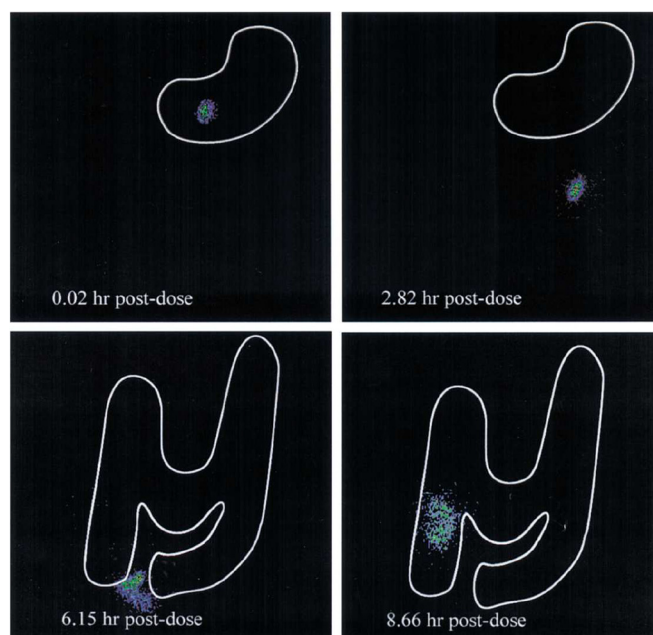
Visualization of drug delivery using gamma scintigraphy from the Eudragit® FS 30 D HPMC capsules in a healthy volunteer (Cole et al., 2002). Reproduced with permission.
